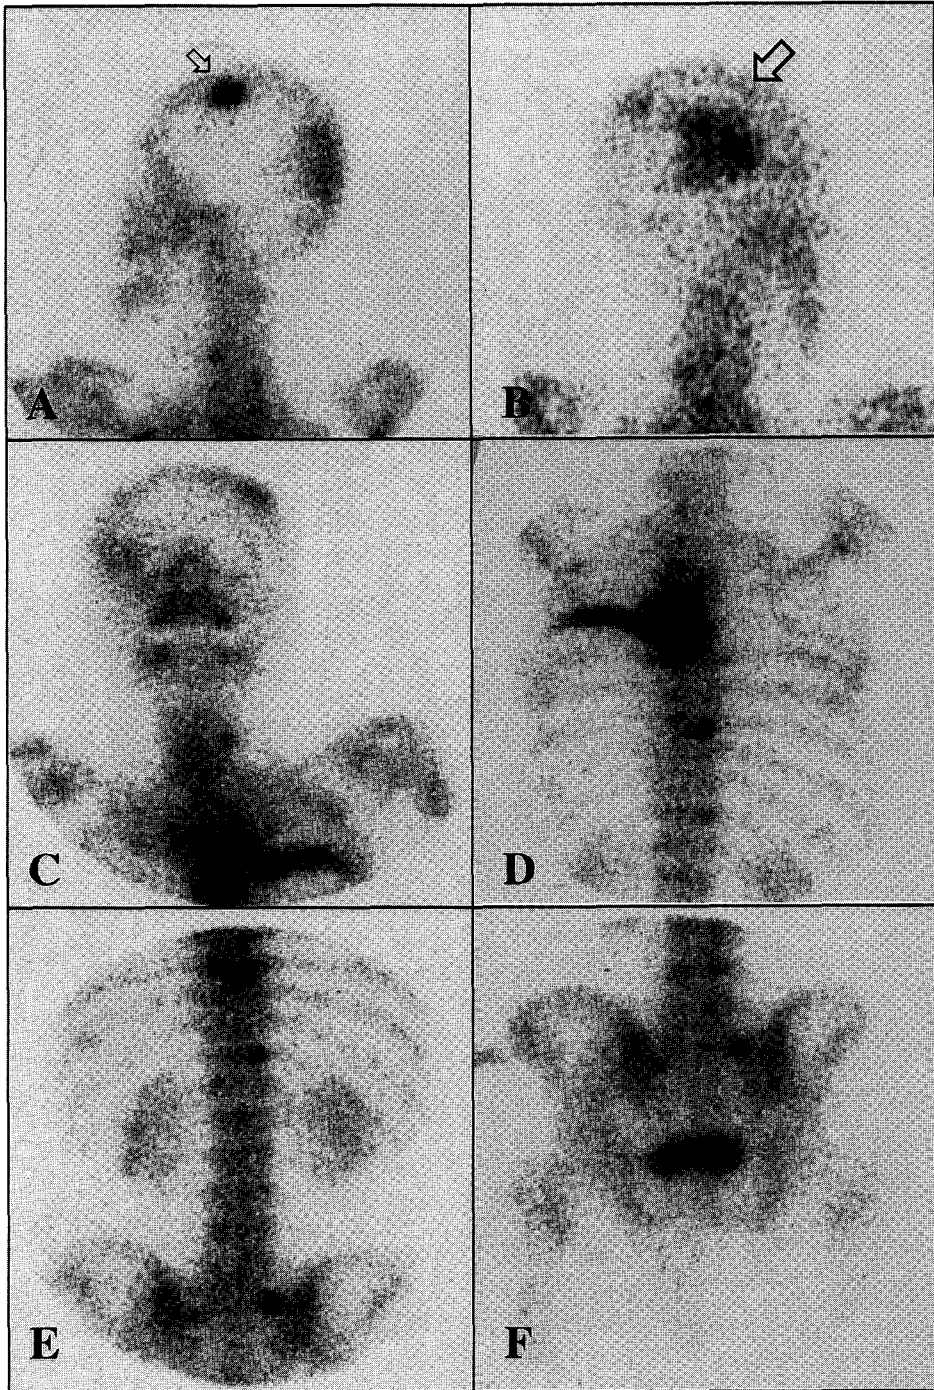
Tc-99m MDP bone scintigraphy (A-F) shows multiple hot spots in the skull, spine, and ribs representing skeletal metastases. Two different patterns of the abnormal uptake of Tc-99m MDP are demonstrated in the skull region (A-C). One lesion on the left (small arrow) represents a bony metastasis and the other on the right (large arrow) represents cerebral infarction.
